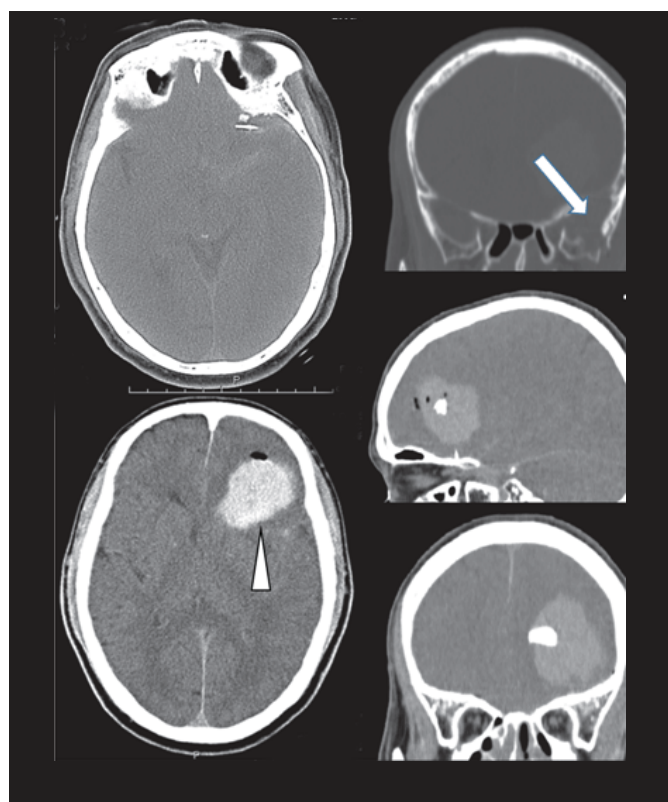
Computed tomography demonstrated right mandibular and sphenoidal bone fracture (white arrow) and intraparenchymal hematoma in the frontal lobe with pneumocephalus (arrowhead).
